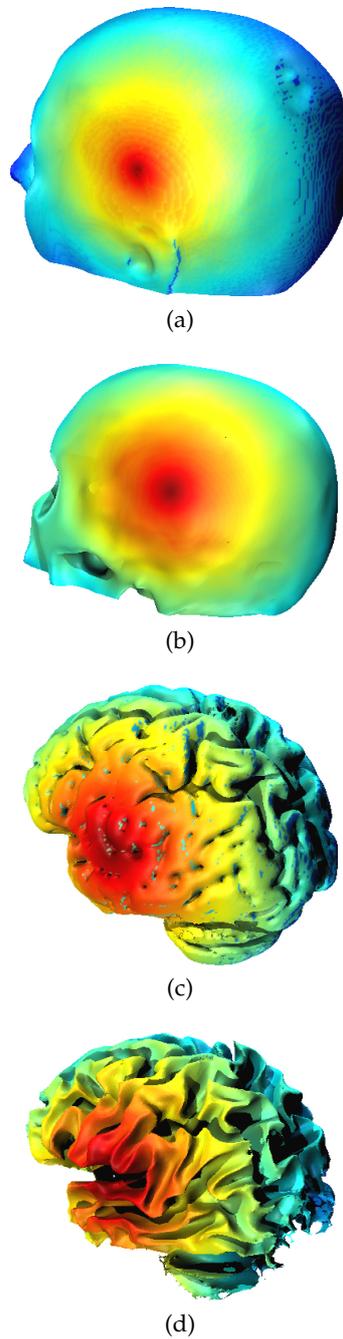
Display of a light distribution with *jet* colormap on the scalp (a), skull (b), grey matter (c) and white matter (d) of a structural MRI of a human head.
